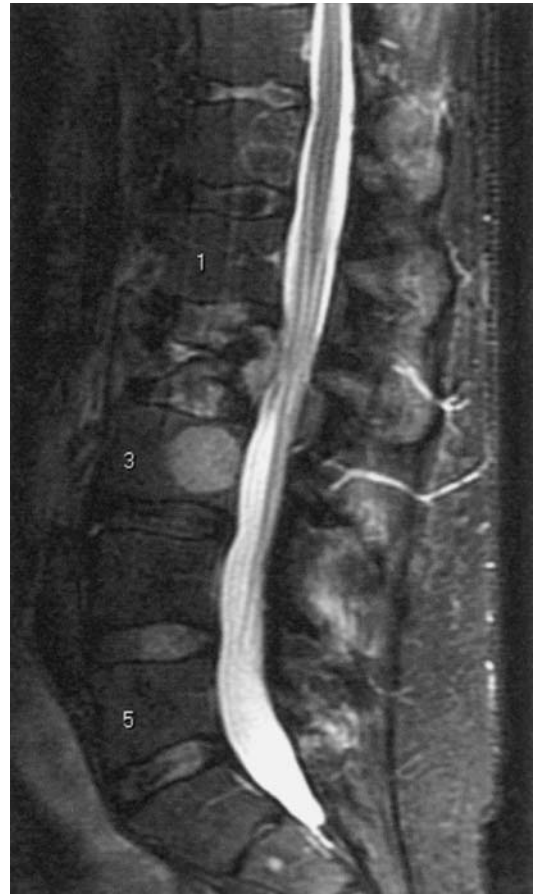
Sagittal T2-weighted MRI (for patient's details, please see Fig. 30.5).
